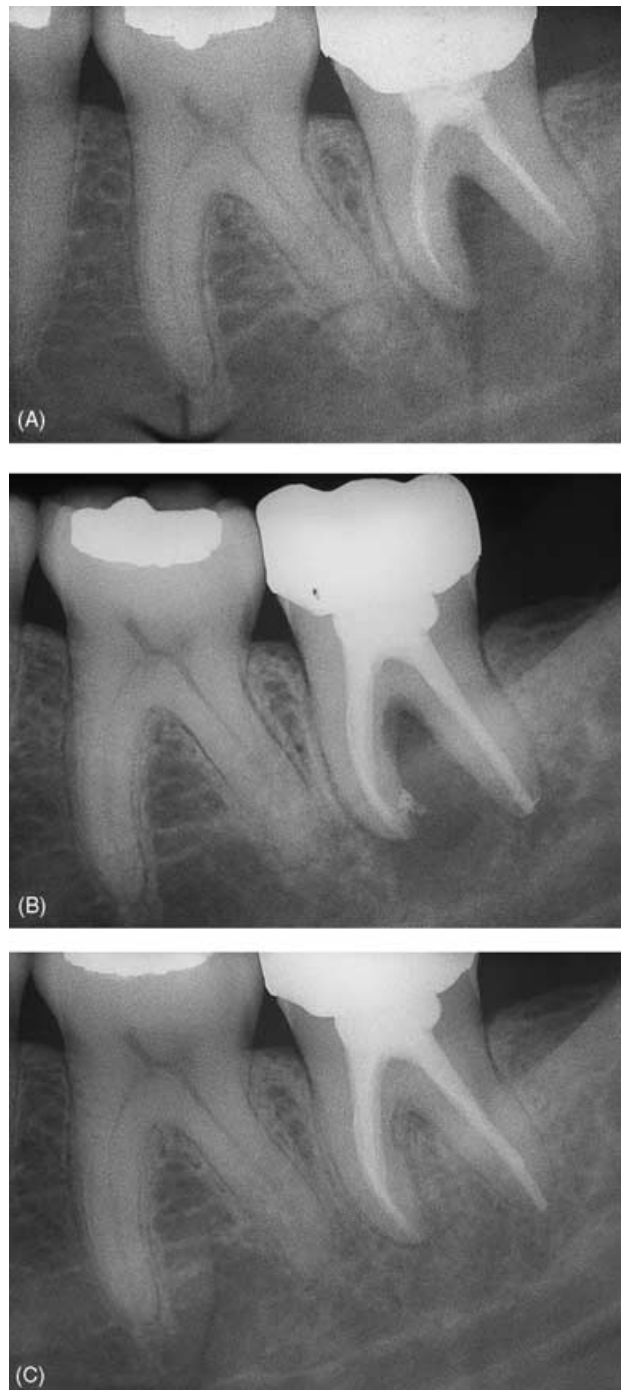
Non-healing due to insufficient root canal preparation and obturation in a mandibular second molar. (A) Radiograph showing a large periapical and furcal radiolucency. (B) Radiograph taken immediately following endodontic non-surgical retreatment. (C) Three-year follow-up radiograph showing evidence of bony healing.
